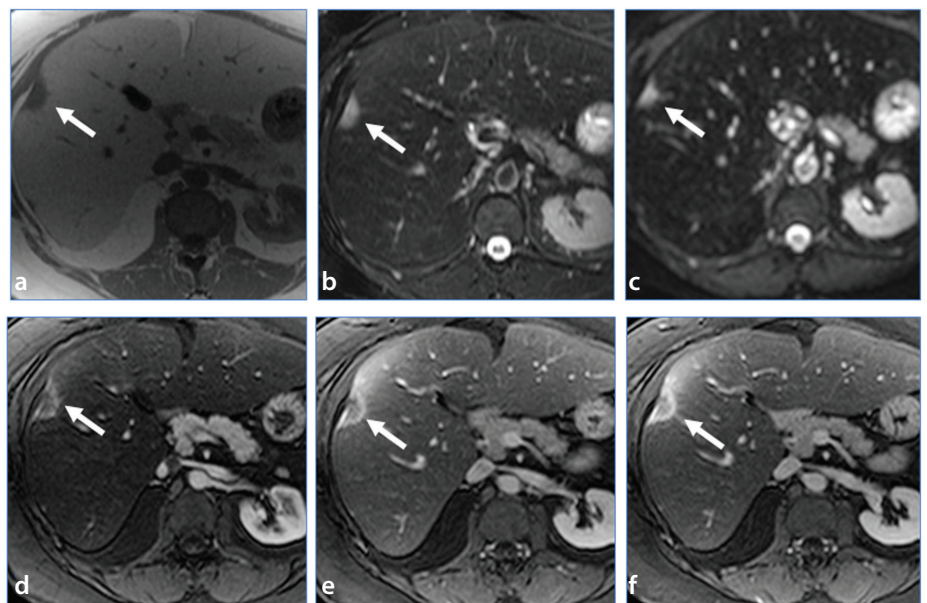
Epithelioid hemangioendothelioma, single. Axial T1-weighted imaging (a), axial T2-weighted imaging with fat suppression (b), axial diffusion-weighted imaging (c), and dynamic post-gadolinium T1-weighted imaging with fat suppression (d-f) show a subcapsular right lobe lesion (arrows) with capsular retraction. The mass demonstrates high T2 signal intensity, low T1 signal intensity, diffusion restriction, and progressive ring-like enhancement following contrast administration.
